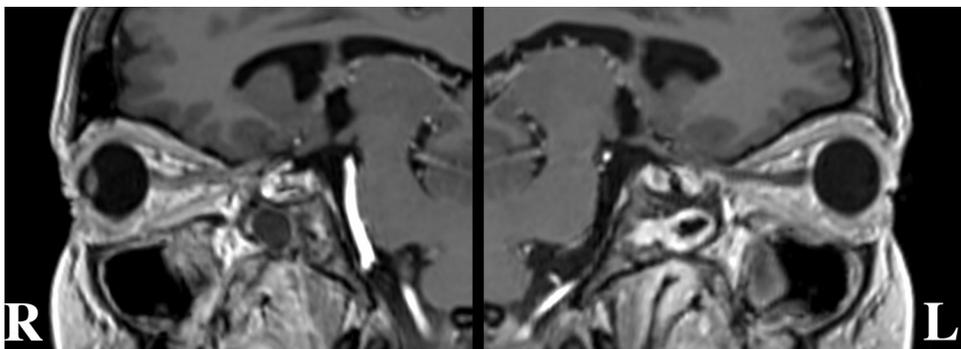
MRI, sagittal sections, comparison of the contrast enhancement observed in the two optic nerves.
